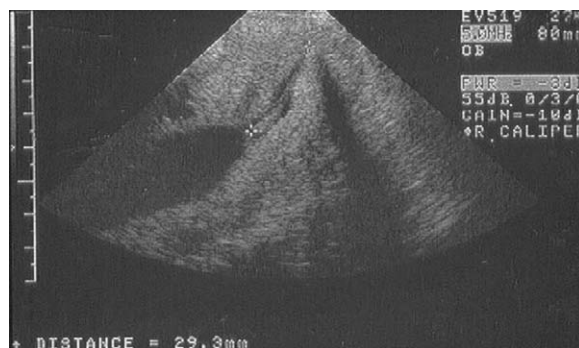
Measurement of cervical length using transvaginal ultrasound. Once adequate visualization is achieved, calipers are placed at internal and external os of the cervix. Cervical length was 29.3 mm.
